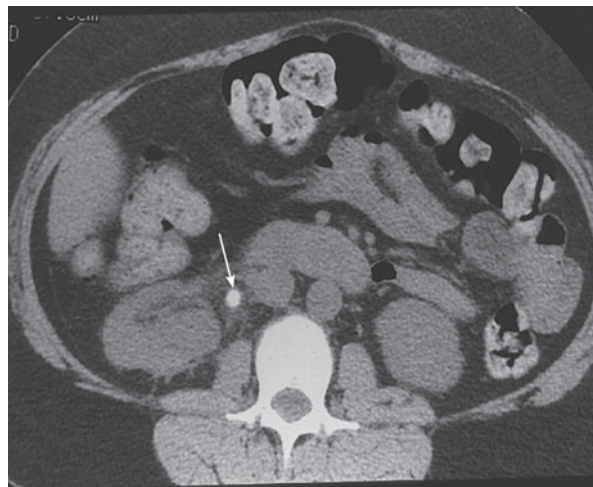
Spiral CT scan of a kidney stone. Shown by the arrow is a kidney stone impacted in the ureter.
